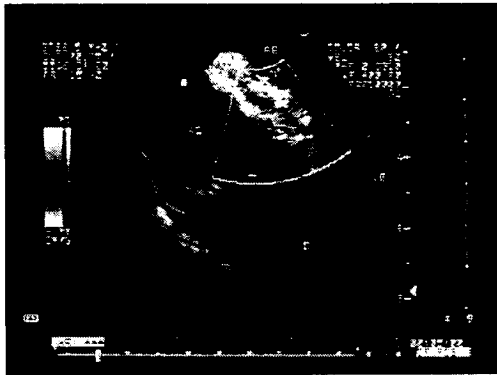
Study with color Doppler revealing no residual shunt. LV - left ventricle; RV - right ventricle; RA - right atrium; LA - left atrium; SVC - superior vena cava.
